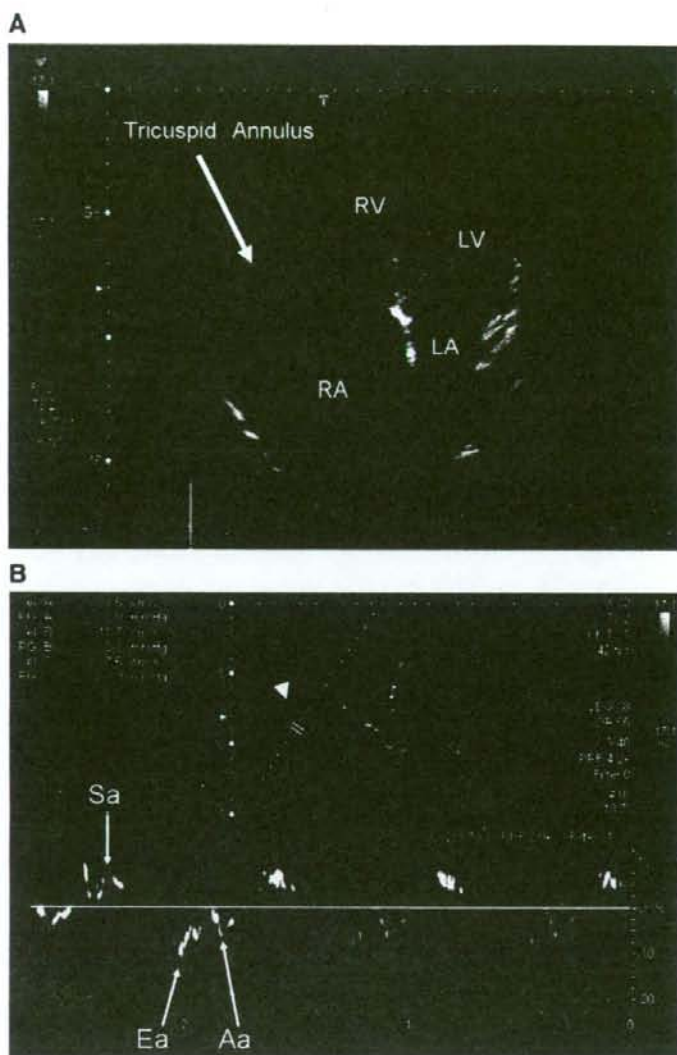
A) Pulsed tissue Doppler image recording with reference point at the tricuspid annulus (arrowhead). RV = right ventricle; RA = right atrium; LV = left ventricle; LA = left atrium. B) Spectral Doppler recording at the tricuspid annulus (arrow). Sa = early systolic velocity; Ea = early diastolic velocity; Aa = late diastolic wave.
